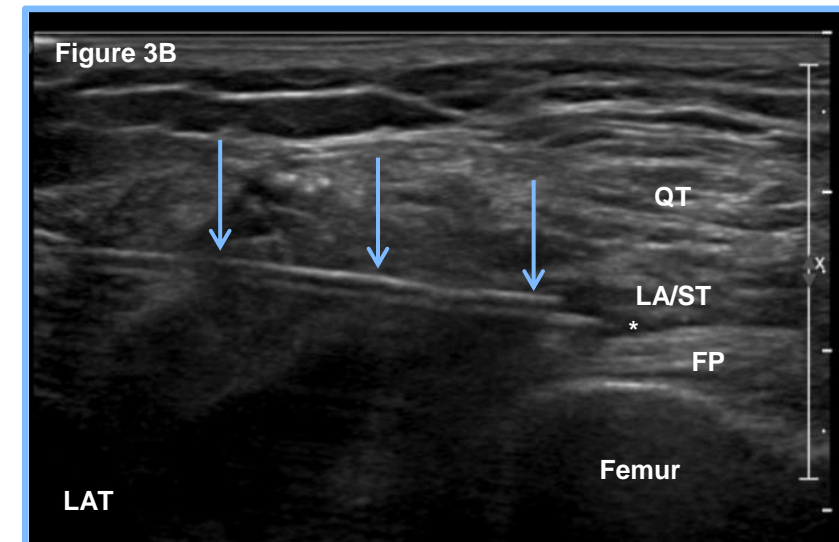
Ultrasound-guided viscosupplementation injection of the right knee. The needle (arrows) tip is within the joint space (\*), which is superficial to the prefemoral fat pad (FP) and deep to the lipoma arborescens / synovial tissue (LA/ST) and quadriceps tendon (QT). LAT=lateral.
